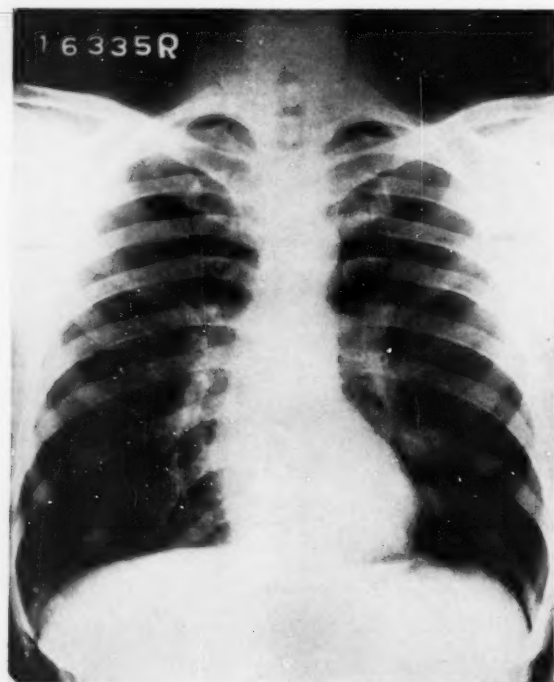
Chest x-ray of Case 3 (E. L. S.) on the 1st hospital day was within normal limits.
